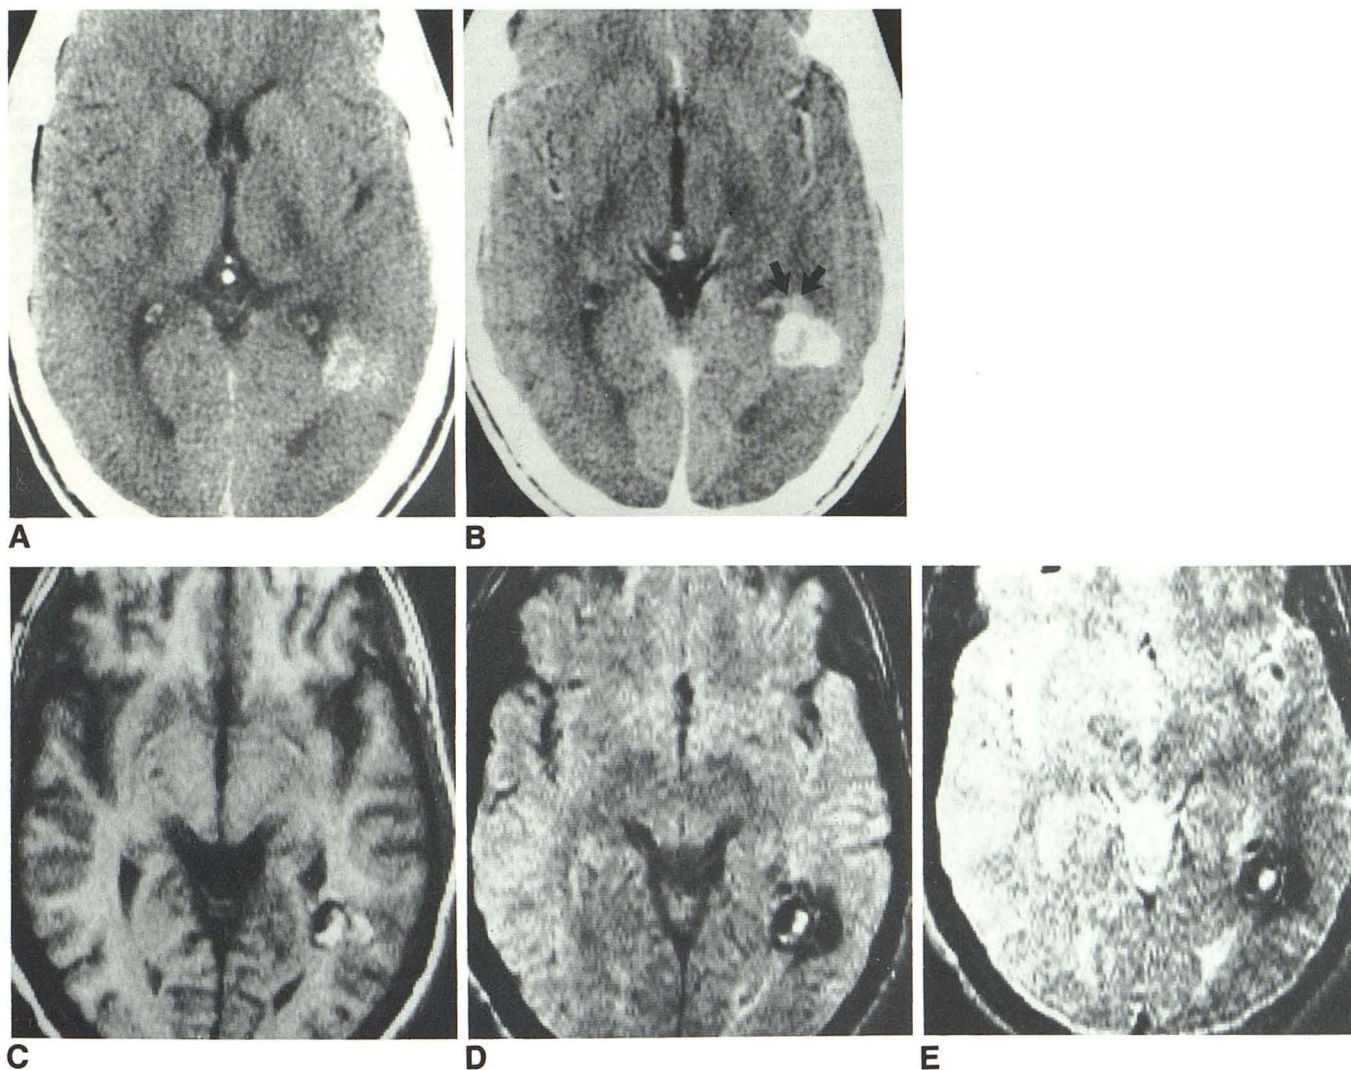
Case 1. A, Plain CT shows heterogeneous hyperdense lesion adjacent to trigone and occipital horn, probably but not definitely including punctate calcifications. B, After contrast, there is moderate heterogeneous enhancement of lesion, with appearance of small vessels anteriorly (arrows). Small vessels were apparent in lateral portion of lesion at time of acute hemorrhage 2½ months earlier (not shown). C, MR, 4 days later. IR 1650/450/
